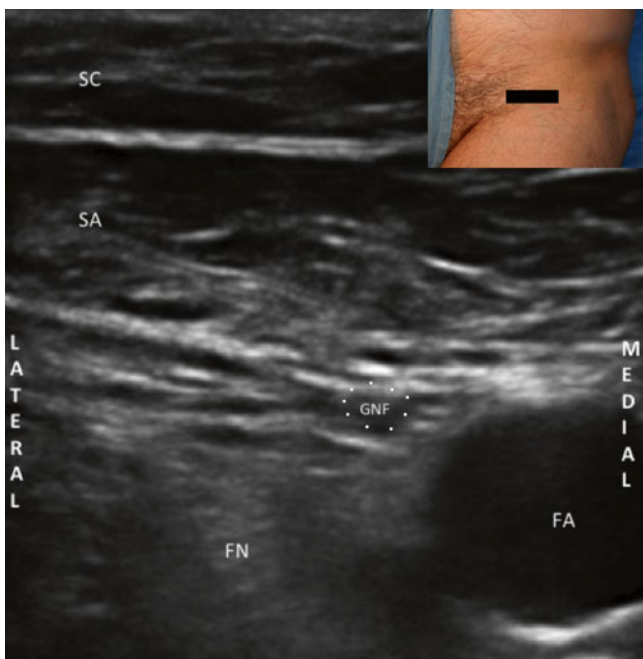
Ultrasound image taken transversely below the inguinal ligament, showing the femoral branch of the genitofemoral nerve. *FA* femoral artery, *FN* femoral nerve, *GNF* femoral branch genitofemoral nerve, *SC* subcutaneous tissue, *SA* sartorius muscle (Image courtesy of Thiago Nouer Frederico, MD)
